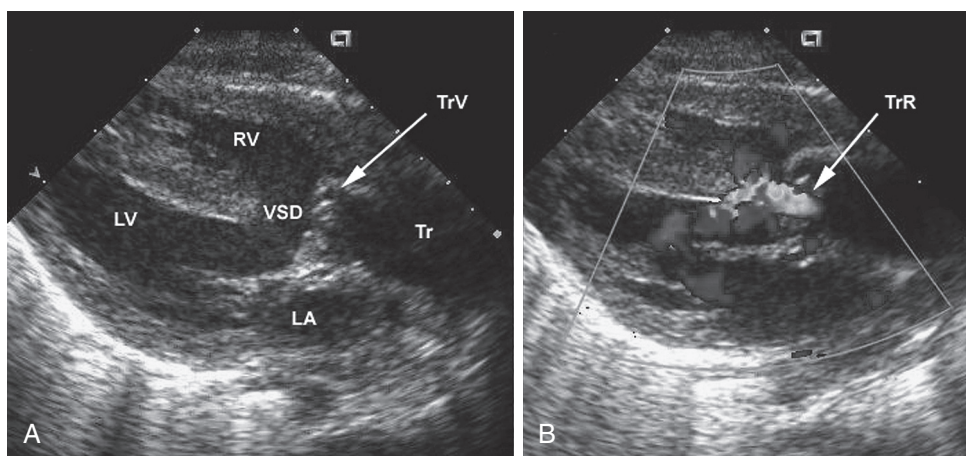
■ Parasternal long-axis view of a patient with truncus arteriosus. A, The large truncus (Tr) overriding the ventricular septal defect (VSD) is demonstrated. B, The addition of Doppler reveals a jet of truncal regurgitation (TrR). LA, Left atrium; LV, left ventricle; RV, right ventricle; TrV, truncal valve.
